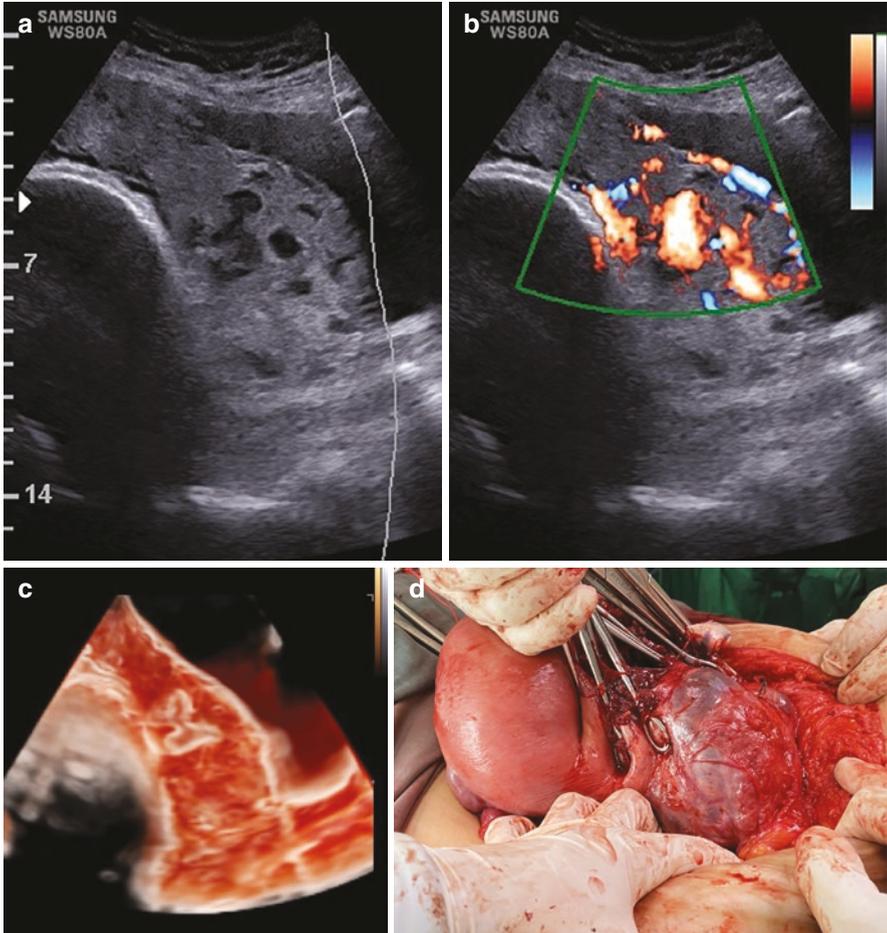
(a) Grayscale ultrasound shows loss of clear zone, abnormal lacunae, placental bulge, and bladder wall interruption. (b) Color Doppler shows uterovesical hypervascularity, bridging vessel, and rail sign. (c) 3D rendering ultrasound shows loss of two parallel lines in uteroplacental-bladder interface with the placental tissue attached in the bladder wall which gives impression for highly suspicious lower bladder invasion. (d) Bladder invasion of PAS FIGO grade 3B with type 4 placental invasion—S2 uterine sector
